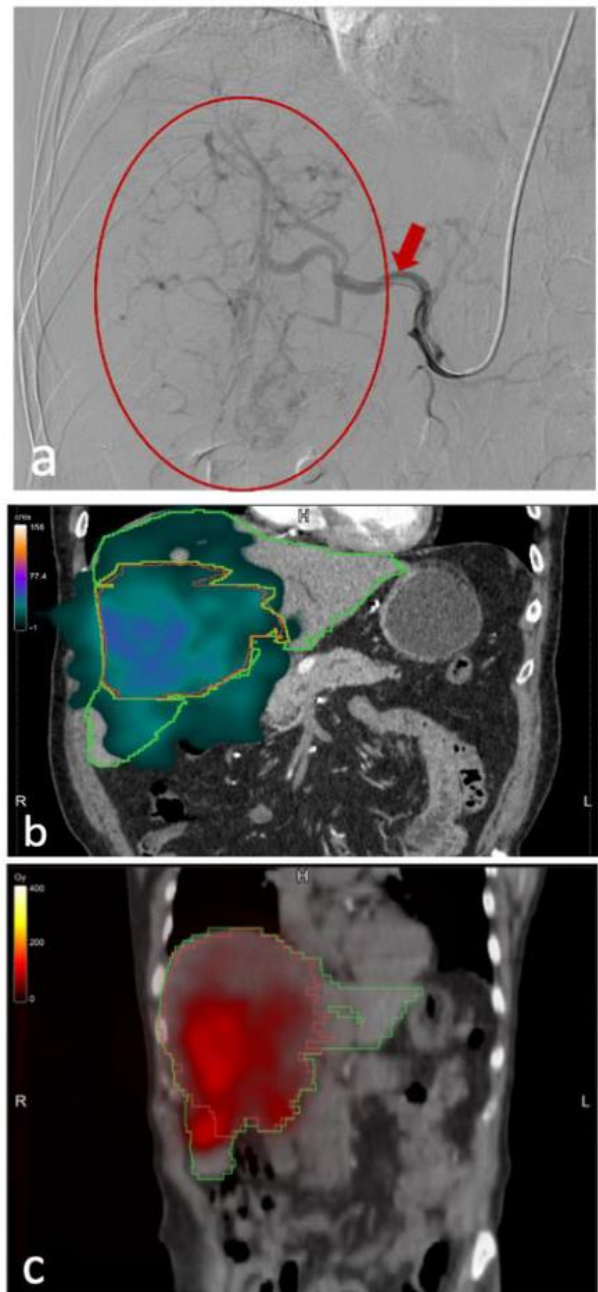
Examples of segmentation and dose delivery process. (a) Hepatic artery selective digital subtraction angiography – well-vascularized liver tumor (circled in red) supplied by branches of the right hepatic artery (arrow); (b) ^{166}Ho microsphere distribution in hepatocellular carcinoma tumor visualized by SPECT/CT methodology with scout dose and (c) treatment dose.
